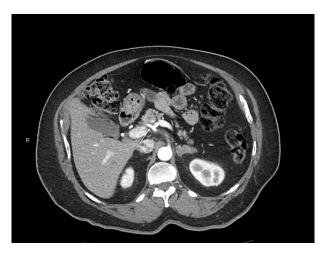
CT view at 2-month follow-up visit showing marked improvement of previously seen soft-tissue thickening along the celiac axis.
